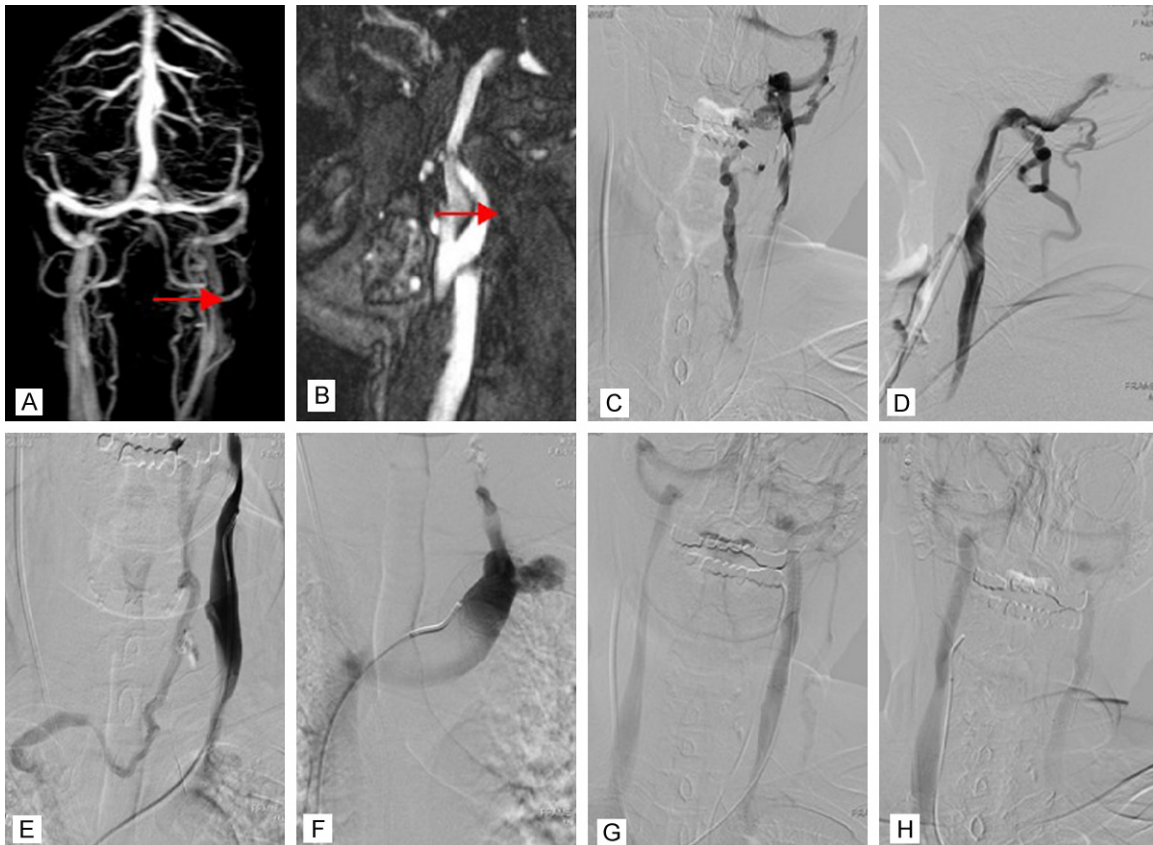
The images of case 2. A, B: MRI test of neck, the arrow means intraspinal spinal epidural hematoma; C-E: Internal carotid angiography and selective IJV catheterization angiography; F: Image after stent placement; G, H: MRI test and color doppler ultrasound test after stent placement for 4 months.
